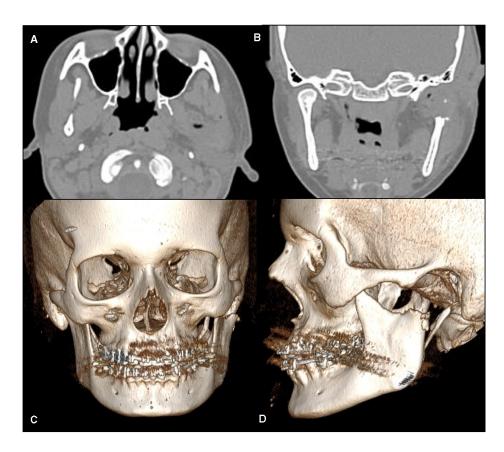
Cone-beam computed tomography of immediate post-operative showing the absence of the left condyle. (A) Axial cutting; (B) coronal reconstruction; (C) front 3D reconstruction; (D) left lateral 3D reconstruction. [Colour figure can be viewed at wileyonlinelibrary.com]
